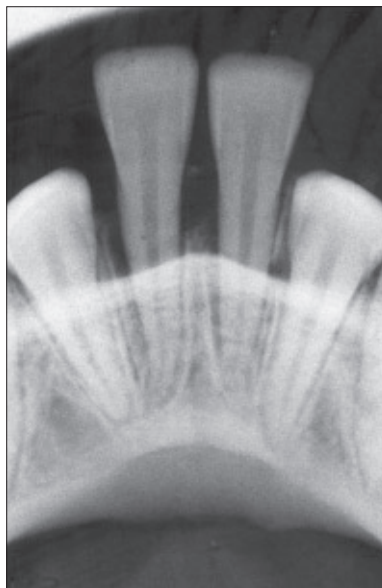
Radiograph showing luxation of permanent lower central incisors.
